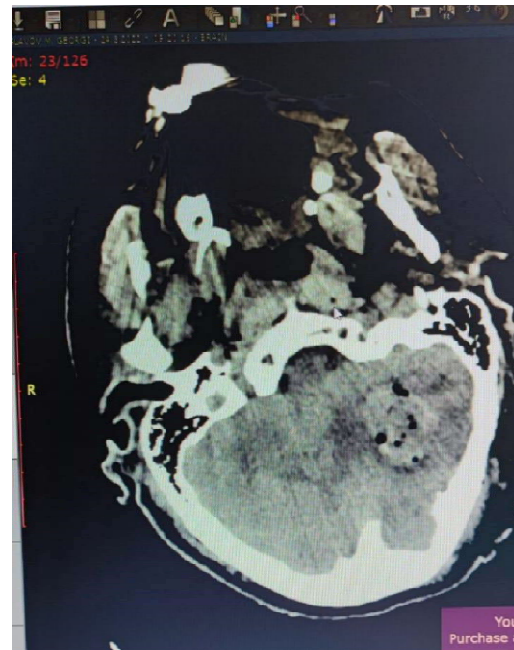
CT, Patient 1, after surgery
